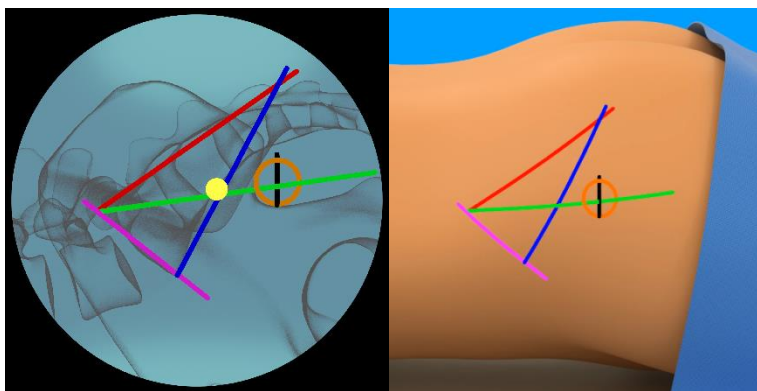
Example of X-Ray overlaid with skin markings
